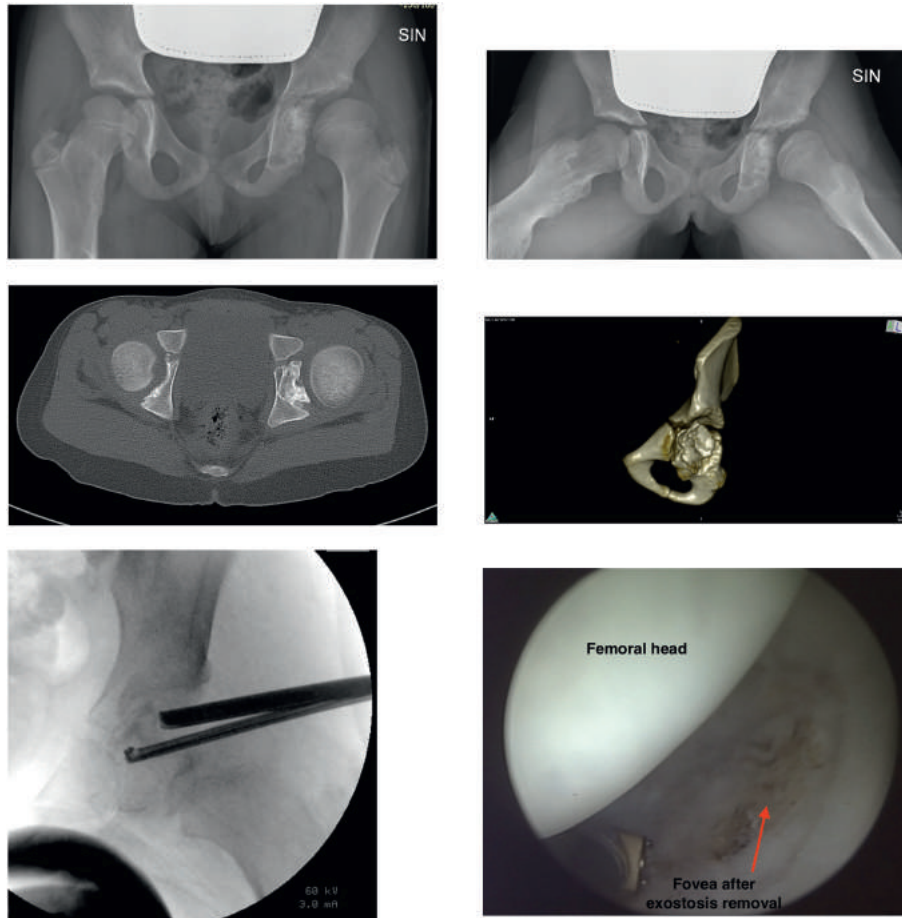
A-B-C-D-E: Preoperative anteroposterior (A) and lateral (B) view showing the intracetabular lesion. Axial view (C) and 3D CT reconstruction (D). Intraoperative image intensifier view (E) and arthroscopic (F) view of the fovea after exostosis removal.
